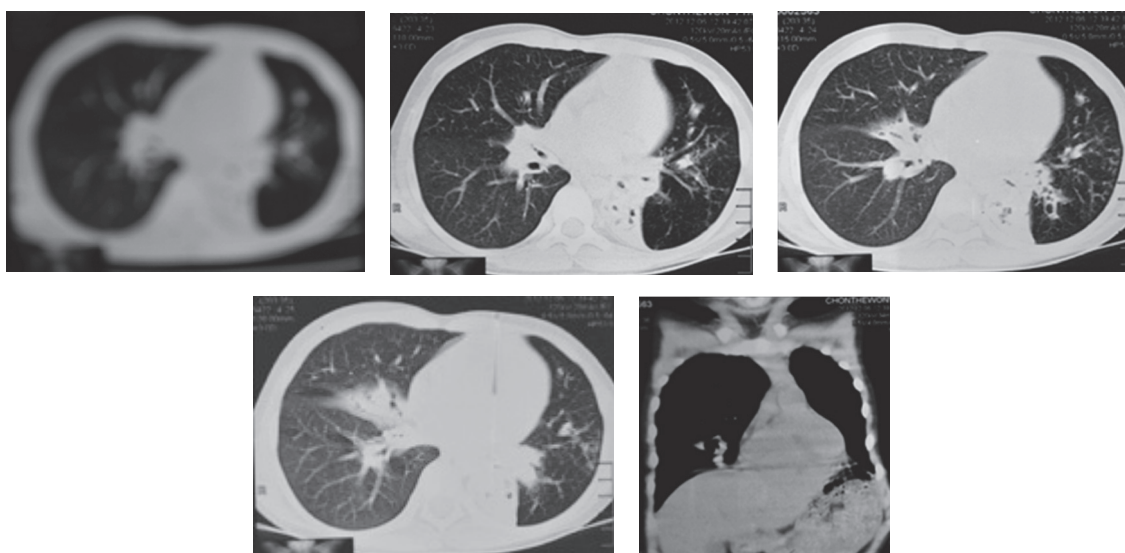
A 7- year- old female patient. A. HRCT image shows parenchymal dense attenuative lesions with air- bronchogram involving the superior segment of the left lower lobe. Another wedge shaped dense attenuating parenchymal lesion is also seen in medial segment of right middle lobe.
